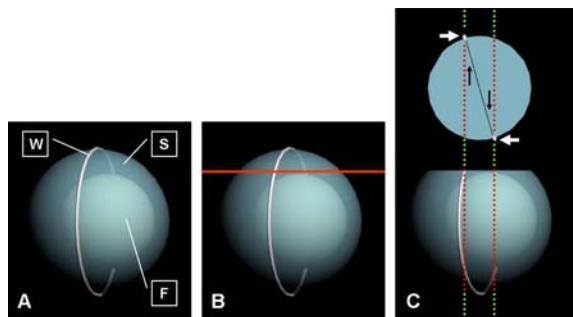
Radiographic anteversion. Principle of the circle theorem method is to evaluate the cup in the area which the femoral component dose not obscure the shadow of the wire marker (Fig. 2A-C are correlated to Fig. 3A-C respectively)
